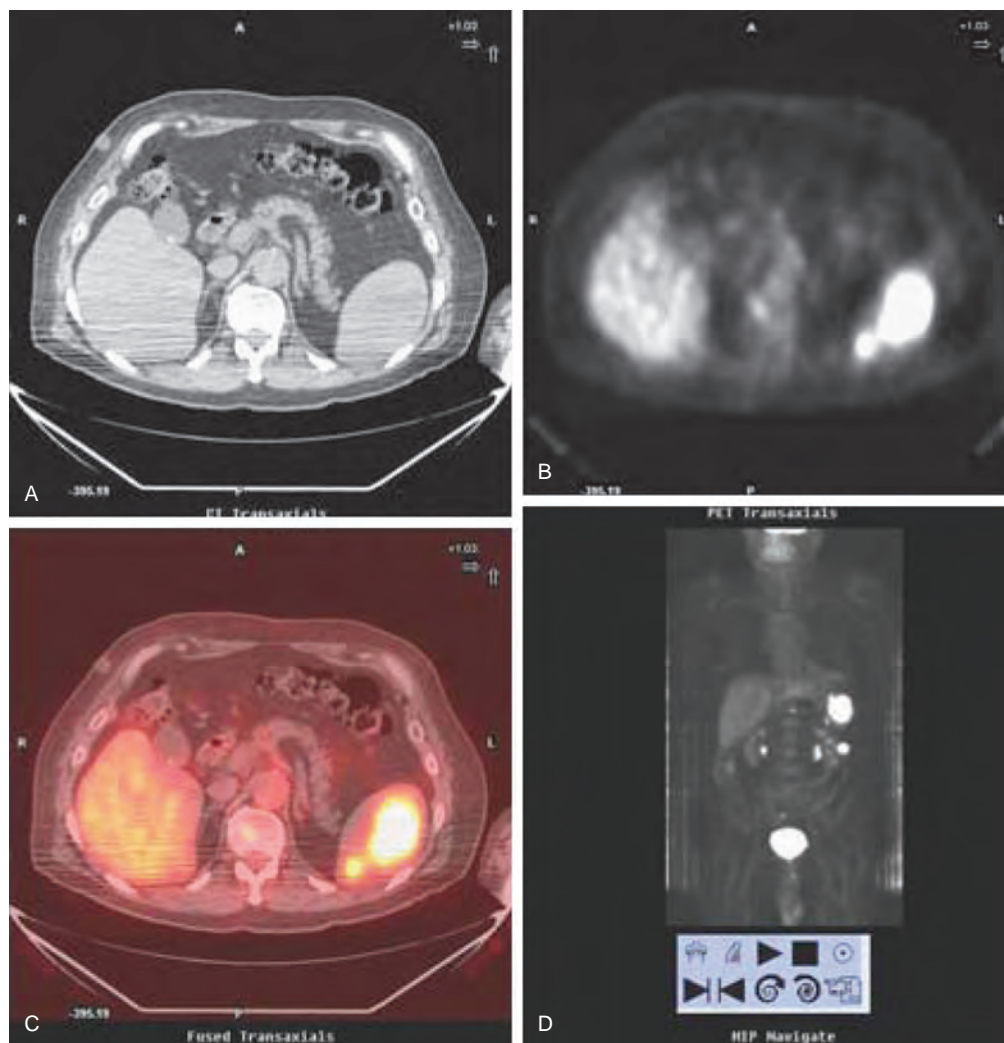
Splenic metastases from a malignant melanoma as imaged by PET/CT. A. The nonenhanced CT scan of the upper abdomen demonstrates a hypodense area centrally in the spleen. B. The axial PET image demonstrates two areas of increased ^{18}F -fluorodeoxyglucose (FDG) activity. C. The fused PET/CT image demonstrates the two FDG-avid lesions localized anatomically within the spleen. D. The maximum intensity projection image demonstrates the large and small (medial) splenic lesions and another lesion inferior to the largest lesion, which projects lateral to the kidney. (Courtesy Terence Z. Wong, MD, PhD, Duke University Medical Center, Durham, NC.)
